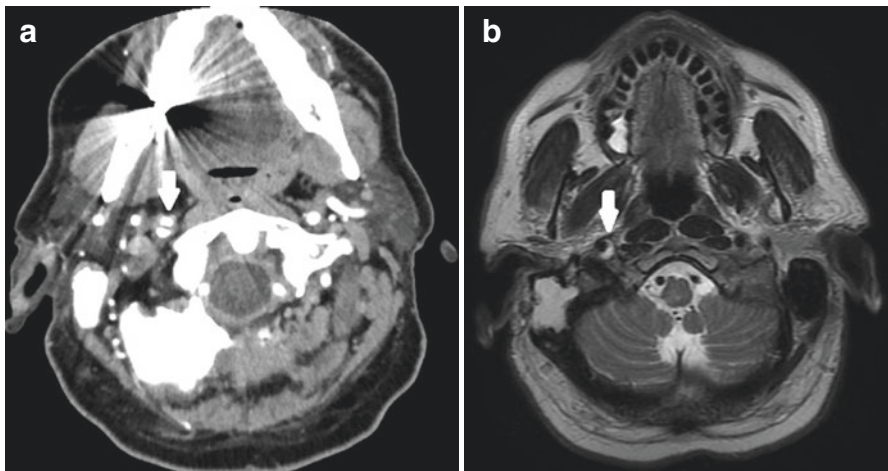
(a) CTA in this case showing a carotid dissection with a double lumen (*arrow*). (b) Axial T1 MRI of another case shows classic hyperintense crescentic typical of a carotid dissection (*arrow*)
